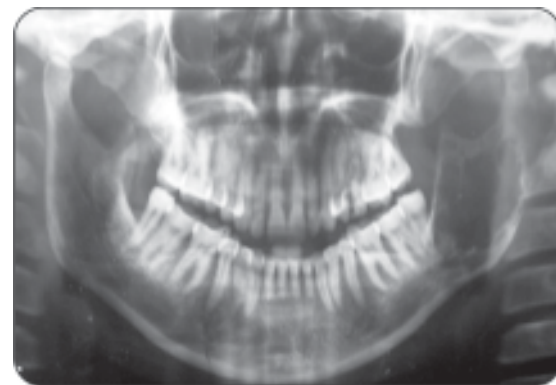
X-ray of neurogenic sarcoma-II
